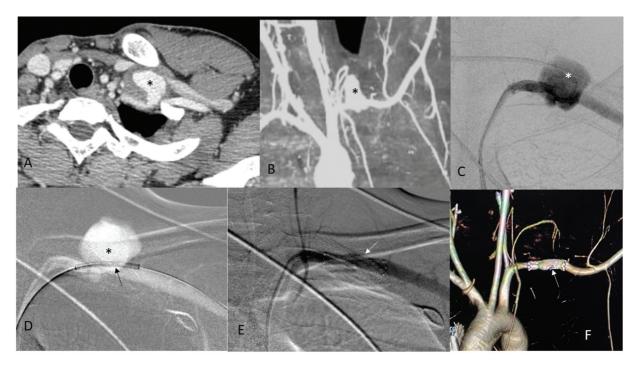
(A) Axial computed tomography (CT) angiography, (B) coronal maximum intensity projection, (C) and digital subtraction angiography images showing the pseudoaneurysm (*) arising from the proximal subclavian artery. (D) Placement of stent (*black arrow*) across the pseudoaneurysm (*). (E) Poststenting DSA run and (F) CT angiography 3 days after deployment of stent (*white arrows*) shows obliteration of pseudoaneurysm.
